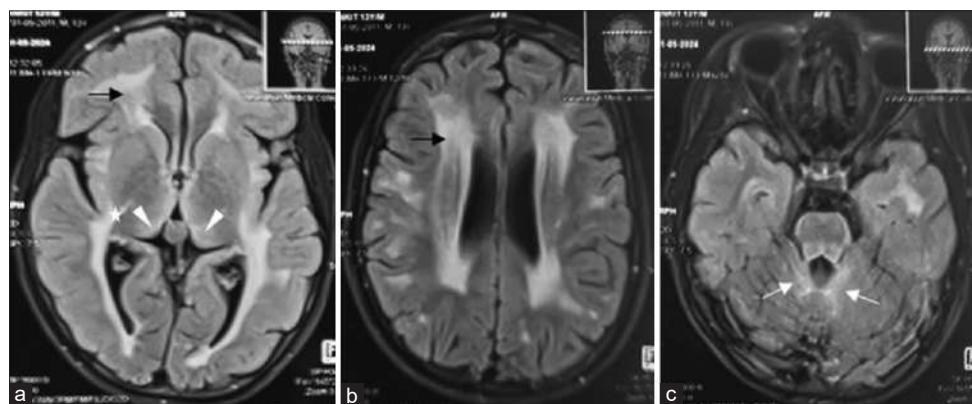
(a-c) Magnetic resonance imaging brain T2 FLAIR imaging shows periventricular hyperintensities (black arrow), internal capsule (white star), thalamus (white arrow head), subcortical white matter abnormalities, and dentate nuclear changes (white arrow)
